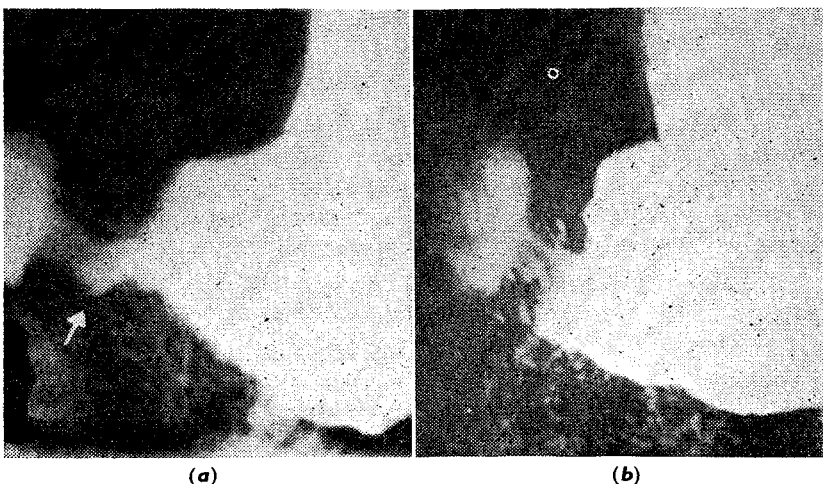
Stomach radiographs: (a) on day 31, showing prepyloric crater (arrow) on 4th day of symptoms; and (b) on day 35, showing complete healing of ulcer.
